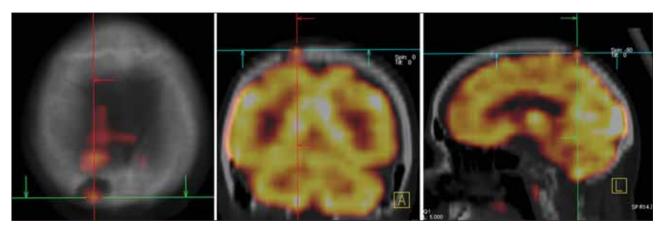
PET-CT scan demonstrating the hypermetabolic area in the right parietal bone.
